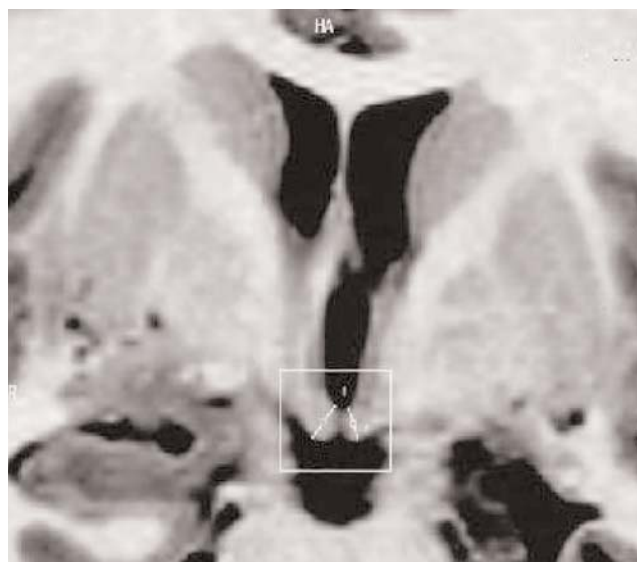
Mamillary body width measurement on a coronal section. From “Morphometry of some elements of limbic system in normal population: a quantitative MRI study” by Yücel K, Hakyemez B, Parlak M, Oygucu IH. *Neuroanatomy* 2002;1:15–21.^[33] © neuroanatomy.org. Reprinted with permission.
